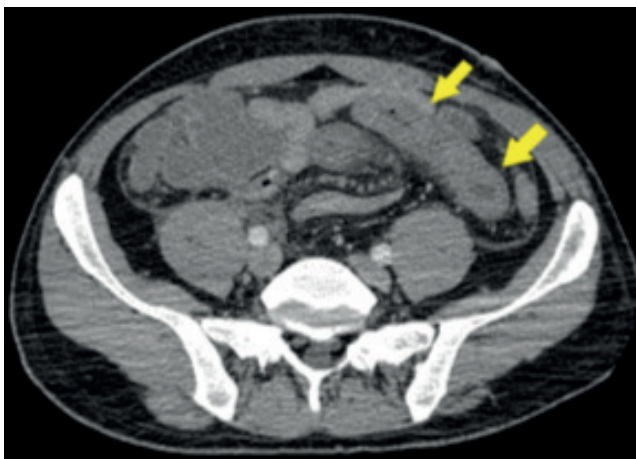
On the CT scan, the oedematous bowel loop in the distal ileum is shown with yellow arrows.
